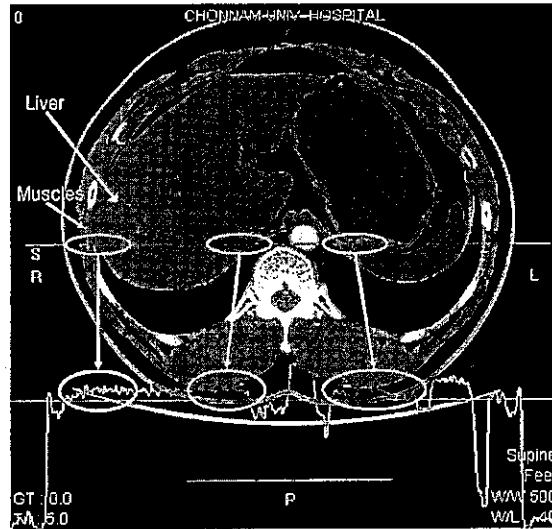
Abdominal CT image.
